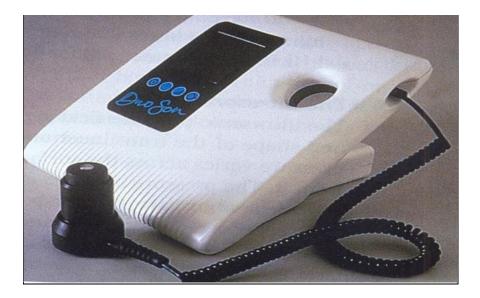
Shows an ultrasound device producing both MHz and kHz frequencies with transducer connected U.S (Taken from Morison et al, 2004).
